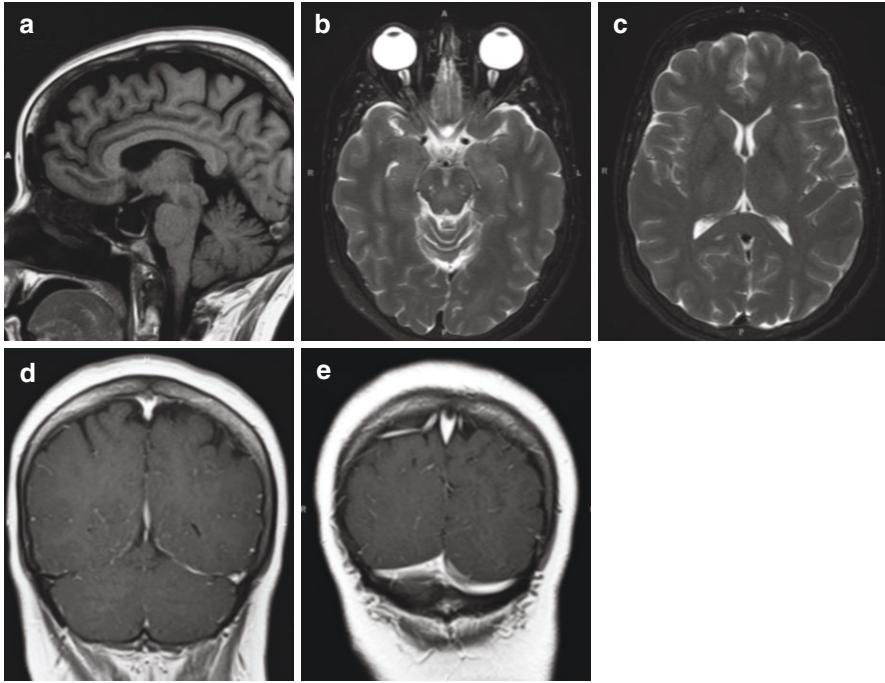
(a) Sagittal T1-weighted image in a patient with IIH demonstrates expanded, partially empty sella. (b) Axial T2-weighted image in the same patient demonstrates expanded optic nerve sheath CSF and flattening of the posterior optic globes. (c) Axial T2-weighted image demonstrates narrowed, slit-like appearance of the lateral ventricles. (d, e) Coronal post-contrast T1-weighted images demonstrate stenosis of the distal right transverse sinus (d) in comparison to the proximal sinus (e)
